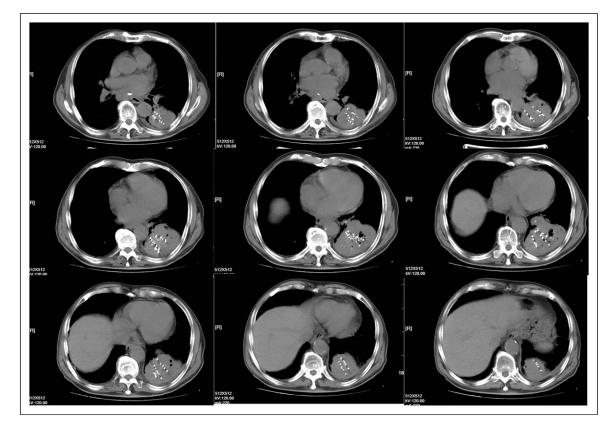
I-125 seeds homogenously spread in lesion on chest CT.
